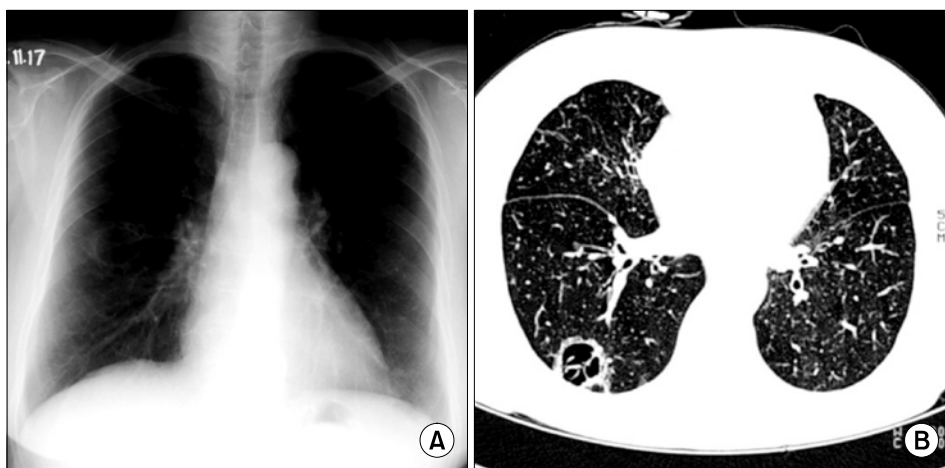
Chest radiography (A) and HRCT scan (B) taken 2 years later, demonstrating that the size of lung mass had increased slightly.
